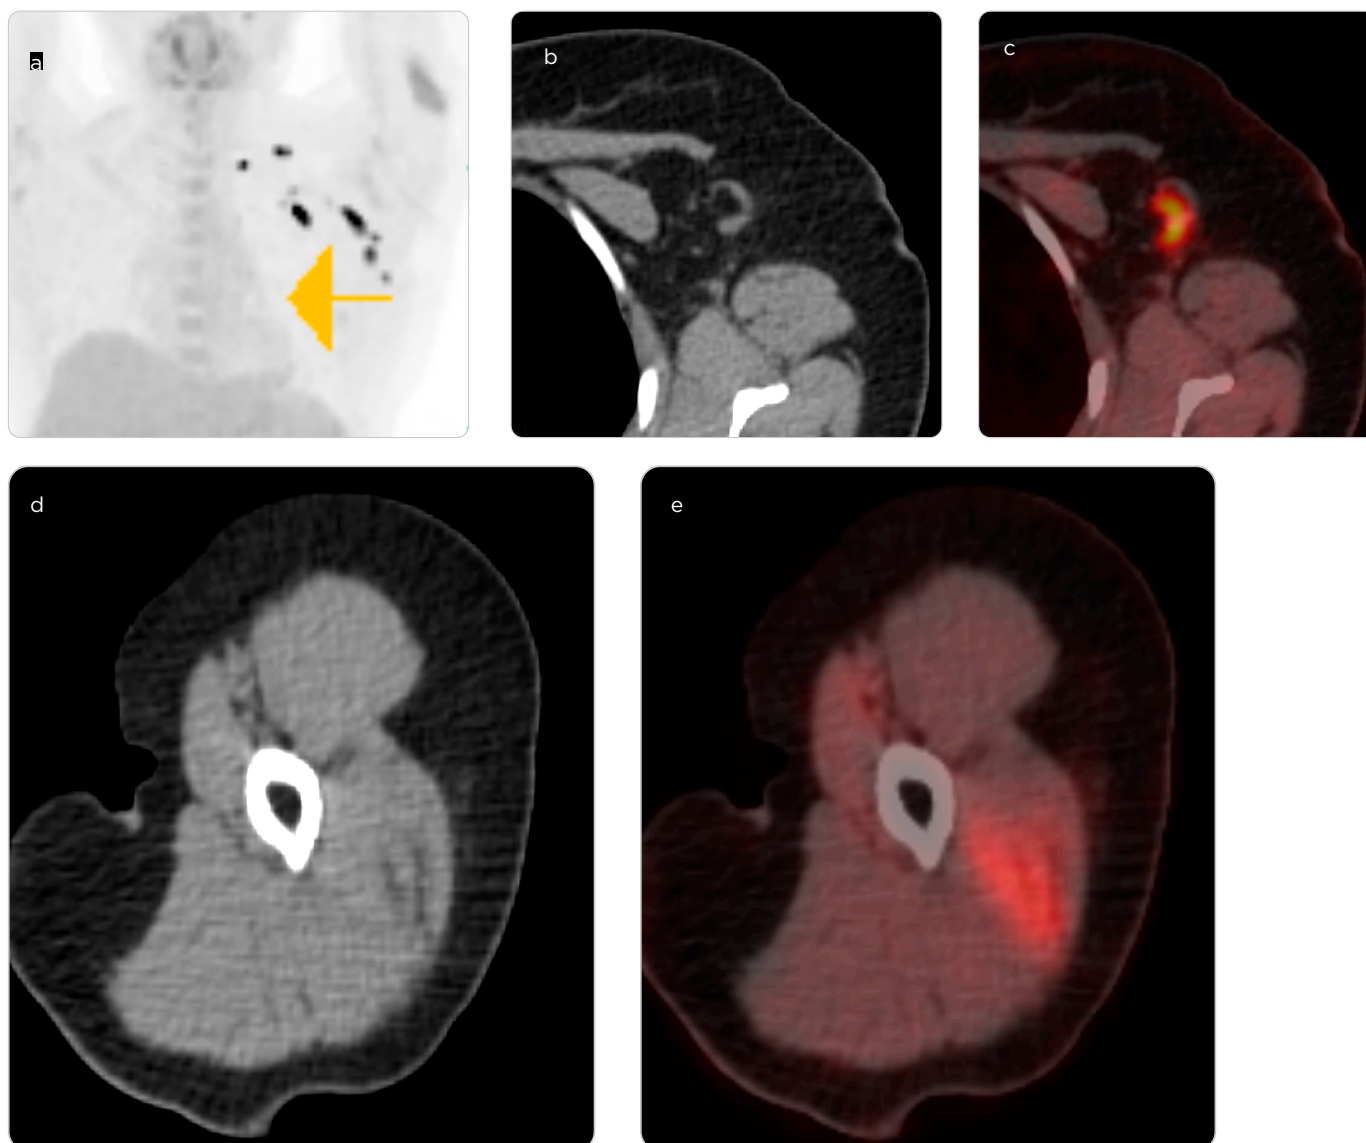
18F-FDG-PET/CT. a) coronal maximum intensity projection (MIP), b) axial CT axillary region, c) axial PET/CT fusion, d) axial CT deltoid region and e) axial PET/CT fusion. Increased FDG uptake in the left reactive axillary and ipsilateral deltoid nodes.
